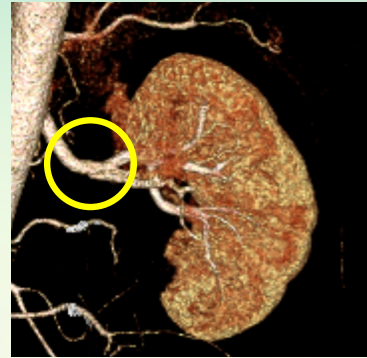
CT Angiogram of Renal Artery Dissection
